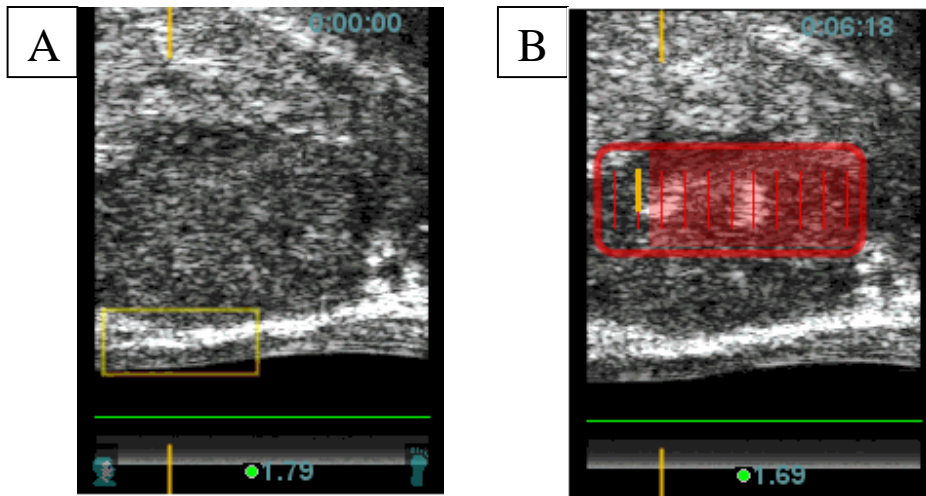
Grade II Uchida changes. Trans-rectal ultrasound image showing saggital plane through mid-gland of prostate. A: pre-treatment image, B: intra-operative image showing discrete grey scale changes within the treatment zone
